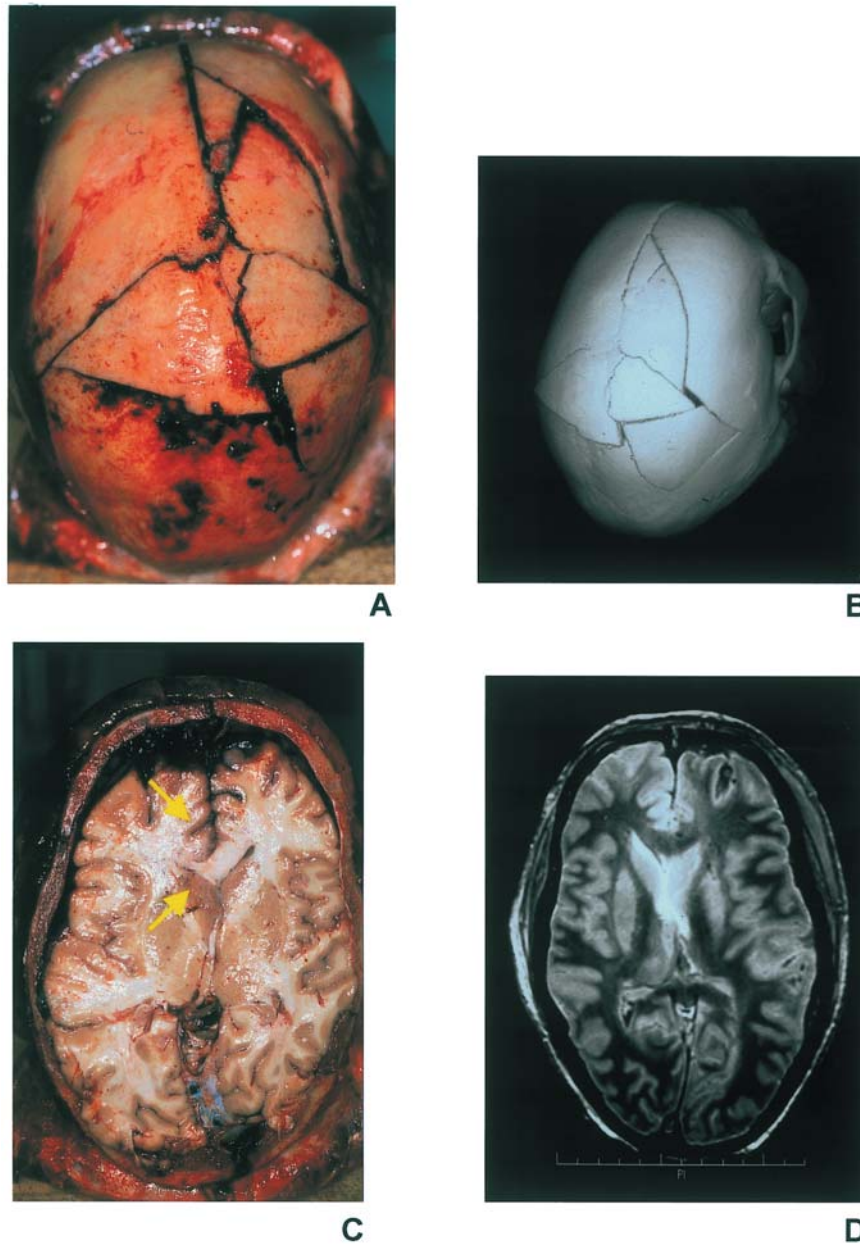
Burst fracture of the calvaria after blunt injury from a falling tree (Case 007): (a) at autopsy; (b) corresponding 3D reconstruction (surface shaded display, 3D-SSD) from the CT data obtained before autopsy; (c) cranial view of brain after Flechsig cut—typical signs of elevated intracranial pressure such as compression of the anterior left ventricle, lateralization and subfalcine herniation with compression of the cingulate gyrus (arrows); (d) corresponding axial fast SE proton density MR image (3600/15), caudal view.
